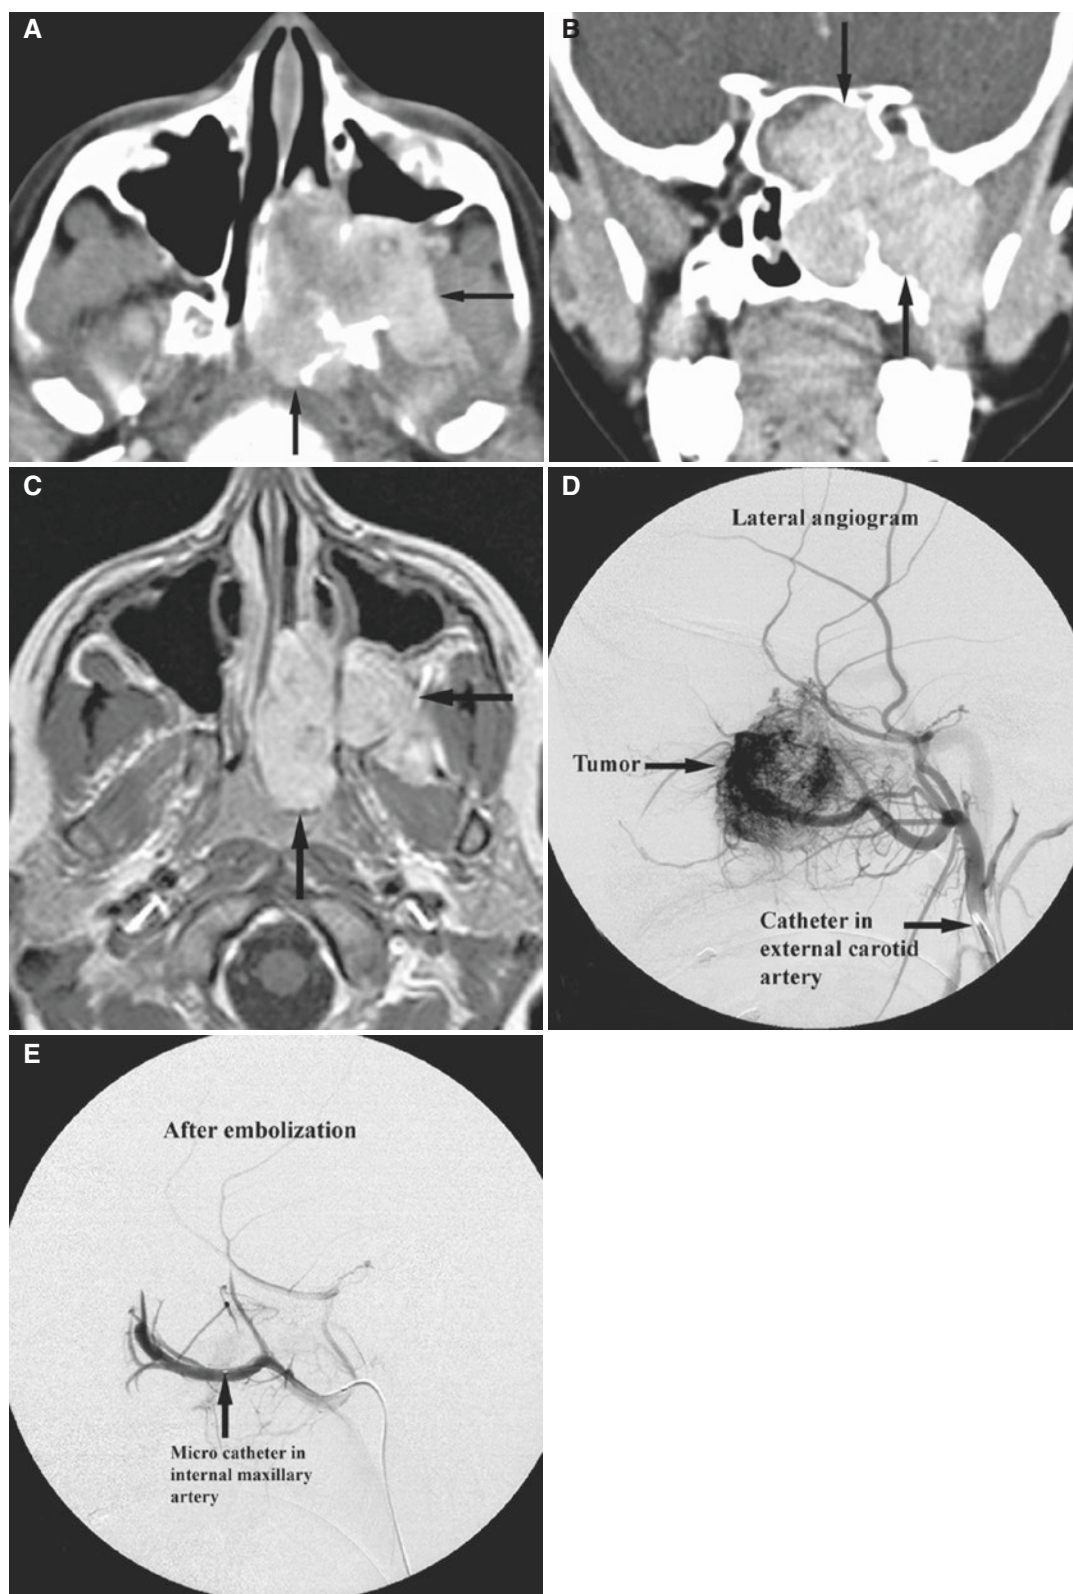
Juvenile angiofibroma embolization. (A) Axial post-contrast CT image shows enhancing mass (*arrows*) in the left nasal cavity, nasopharynx, maxillary sinus, and infratemporal fossa with bone destruction. (B) Coronal post-contrast CT image shows enhancing mass (*arrows*) in the left sphenoid sinus, left nasal cavity, left maxillary sinus, and left infratemporal fossa. (C) Axial T1-weighted post-Gd MRI shows intensely enhancing mass (*arrows*). (D) Digital subtraction
